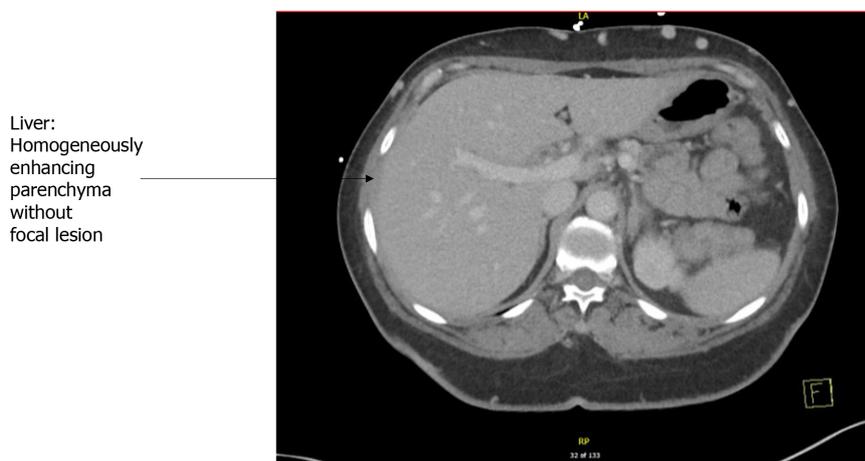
Computed tomography scan of abdomen.
